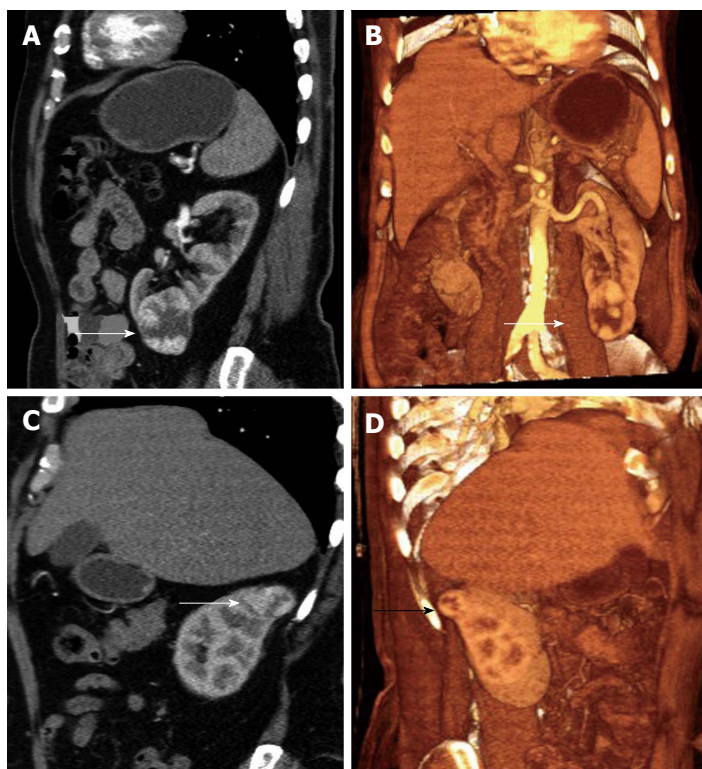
The 74-year-old man with synchronous bilateral renal cell carcinomas of clear cell type (stage T1). Bilateral synchronous renal cell carcinomas (RCCs) are uncommon, reported in less than 2% of patients with RCCs. The patient had left radical nephrectomy and right partial nephrectomy. Sagittal multiplanar reformations (MPR) (A) and coronal 3D reformation with volume rendering technique (B) during the corticomedullary phase depict a sharply-demarcated tumor in the lower pole of the left kidney (arrow, A), strongly and heterogeneously enhancing. Sagittal (C) MPR and (D) 3D reformation with the same algorithm depict a second, smaller tumor in the upper pole of the right kidney, with a similar pattern of contrast enhancement. Preoperative information obtained with computed tomography examination enabled conservative surgery for the right renal malignancy.
